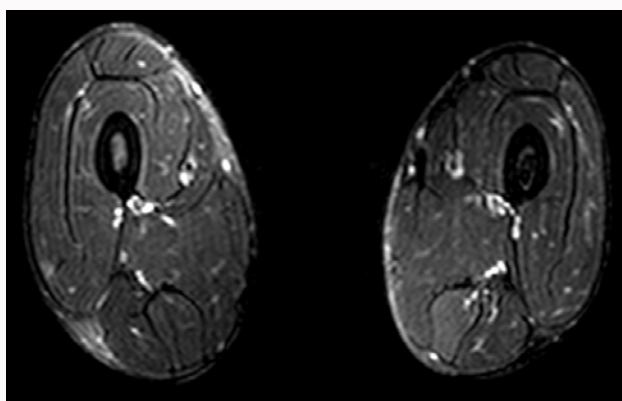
Magnetic resonance imaging (MRI) of the thigh.
